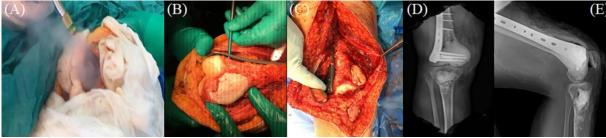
Intra-operative images of liquid nitrogen application (A), cementing (B), and internal fixation (C) with postoperative radiographs (D, E)
